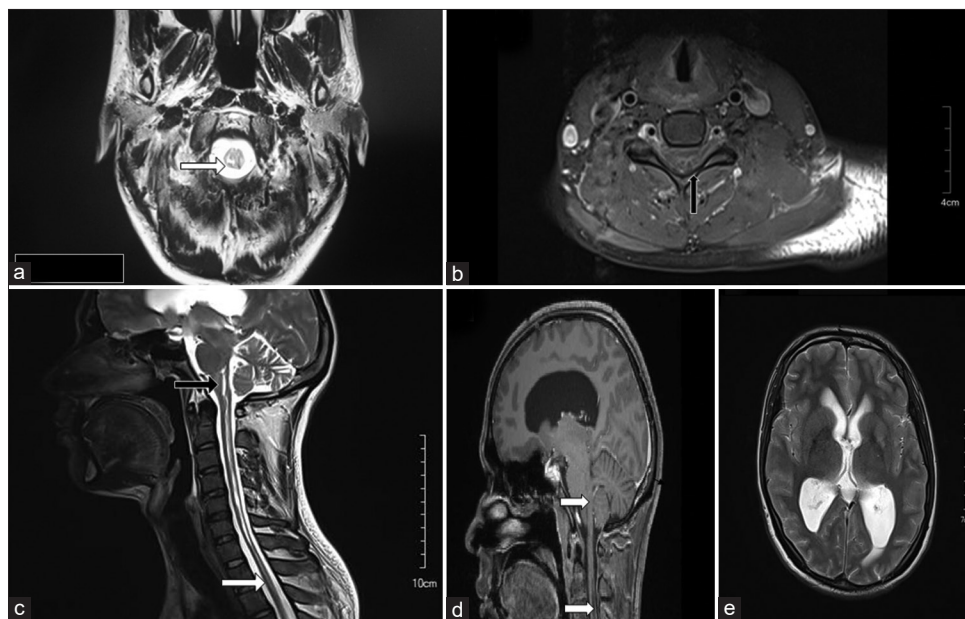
(a) T2-weighted axial images showing syrinx in the cervical cord at the C5 level. (b) Post-contrast T1-weighted axial images showing syrinx in the cervical cord at the C5 level. (c) T1-weighted sagittal cervical spinal cord MRI showing linear T2 hyperintensity involving the cervical cord extending up to the medulla and lower pons consistent with syringomyelia with syringobulbia (arrows). (d) T1-weighted sagittal brain MRI with gadolinium contrast showing no abnormal enhancement along the cord and visible brain parenchyma (arrows). (e) T2-weighted axial brain MRI showing mild dilation of ventricular system with no periventricular oozes (arrows). *Black arrow shows syringobulbia, while the white arrow shows syringomyelia
